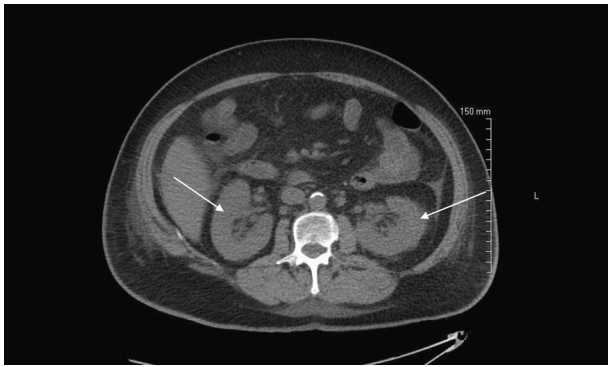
Axial CT image demonstrating bilateral adrenal gland enlargements and diffuse hemorrhage (arrows).
